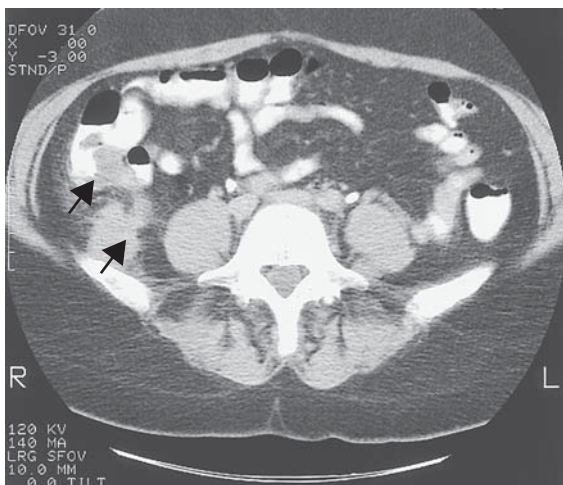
The CT demonstrates the cecal mass with posterior extramural extension.
